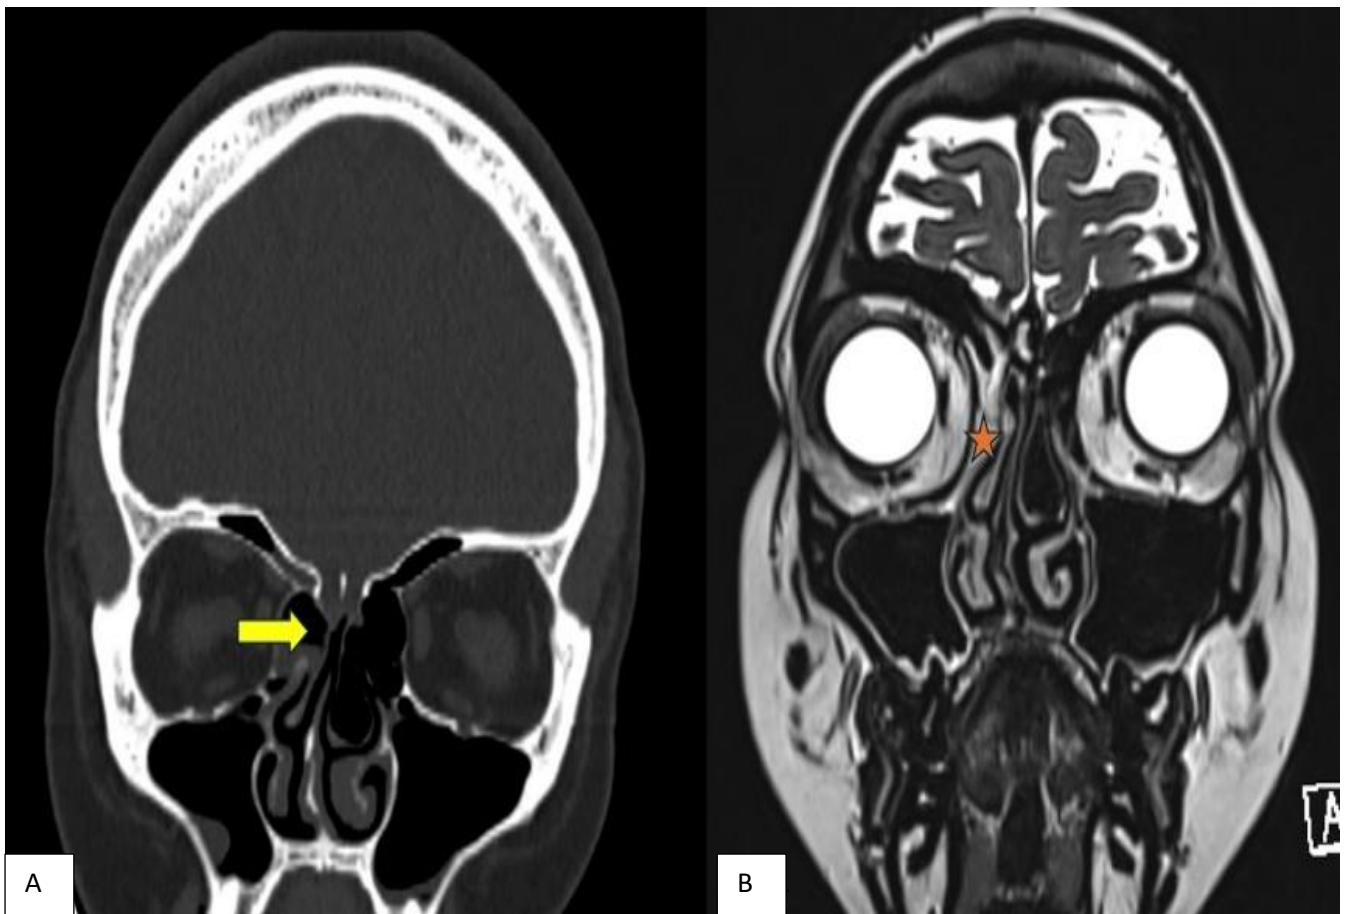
(A and B): A: Non contrast CT scan coronal view showing the site of the defect in the right ethmoid roof and rarefaction of both cribriform plates suggestive of sites of CSF rhinorrhoea (yellow arrow). B: MRI drive sequence coronal view image showing CSF signal herniating through the right cribriform plate suggestive of a skull base defect (red asterisk).
